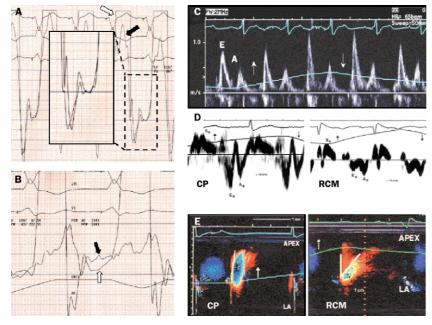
Haemodynamic and echocardiographic findings in constrictive pericarditis CP=constrictive pericarditis, RCM=restrictive cardiomyopathy, LA=left atrium. Up arrow=onset of inspiration. Down arrow=onset of expiration. A: Simultaneous pressure tracings from left (white arrow) and right (black arrow) ventricles showing equalisation of diastolic pressures with typical dip and plateau or square-root pattern (enlarged in box). In cycle at left, pressure at plateau=27% of peak right-ventricular systolic pressure. B: Respiratory variation in simultaneous left ventricular (white arrow) and pulmonary capillary wedge (black arrow) pressure tracings due to dissociated intrathoracic and intrapericardial pressures. C: Respiratory variation in early diastolic transmitral flow velocities are measured by pulsed-wave doppler as consequence of increased interventricular interdependence and dissociation of intrathoracic and intrapericardial pressures. Velocities are 27% lower at onset of inspiration (up arrow) and higher at onset of expiration (down arrow). D: Tissue doppler imaging showing increased (15 cm/s) peak early diastolic mitral annular velocities (Ea) in CP. By comparison, peak annular velocities (Ea) are decreased (4 cm/s) in RCM due to abnormal longitudinal myocardial relaxation. E: Colour doppler M-mode echocardiography of diastolic flow from LA towards ventricular apex imaged in four-chamber view. Velocity of propagation of early left ventricular flow measured as slope of first aliasing contour (white line) is steep (110 cm/s; normal range 50-80 cm/s) in CP, but is delayed (25 cm/s) in RCM, reflecting abnormal myocardial relaxation. Adapted with permission of Excerpta Medica from Rajagopalan N, Garcia MJ, Rodriguez L, et al. Comparison of new Doppler echocardiographic methods to differentiate constrictive pericardial heart disease and restrictive cardiomyopathy. Am J Cardiol 2001; 87: 86-94 (reference 126).
